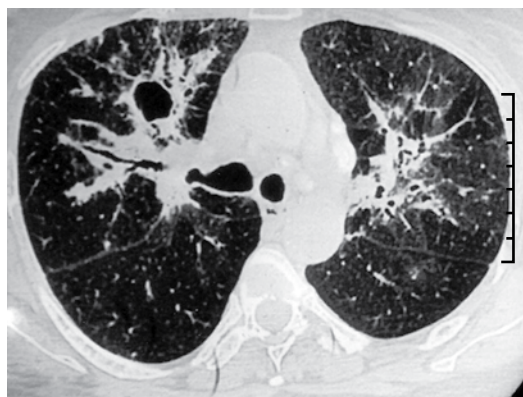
CT scan of the chest, obtained 9 months prior to referral, showing a well-defined cavitary lesion in the anterior segment of the right upper lobe. Bronchovascular bundles with a beaded appearance can also be seen.
